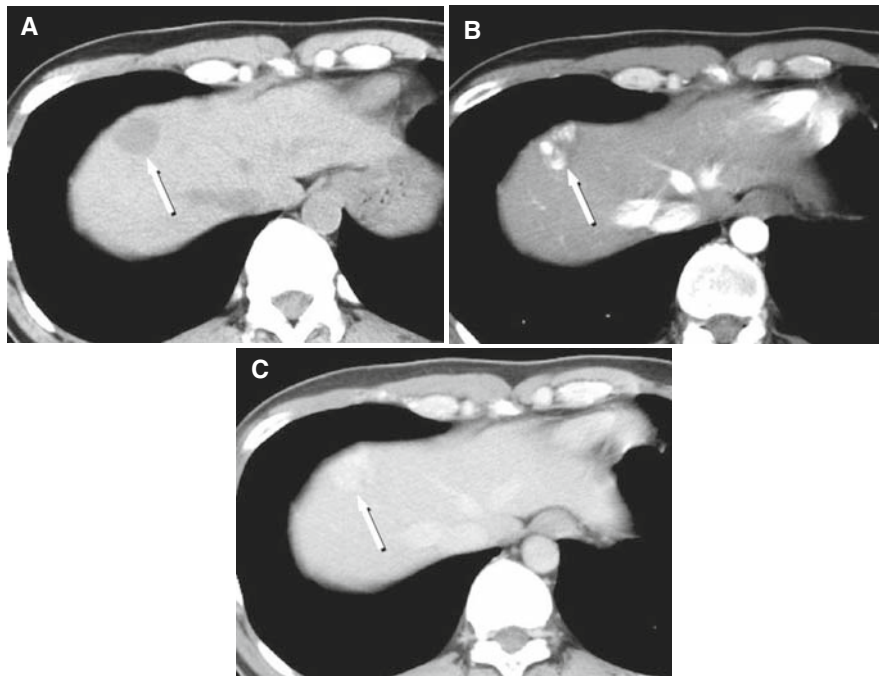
Small cavernous hemangioma. (A) Unenhanced CT. (B) Arterial phase-enhanced CT. (C) Portal venous phase CT. A 1 cm nodule (*arrow*) in the lateral segment is isodense with blood vessels on all three phases identifying it as an hemangioma rather than HCC.
